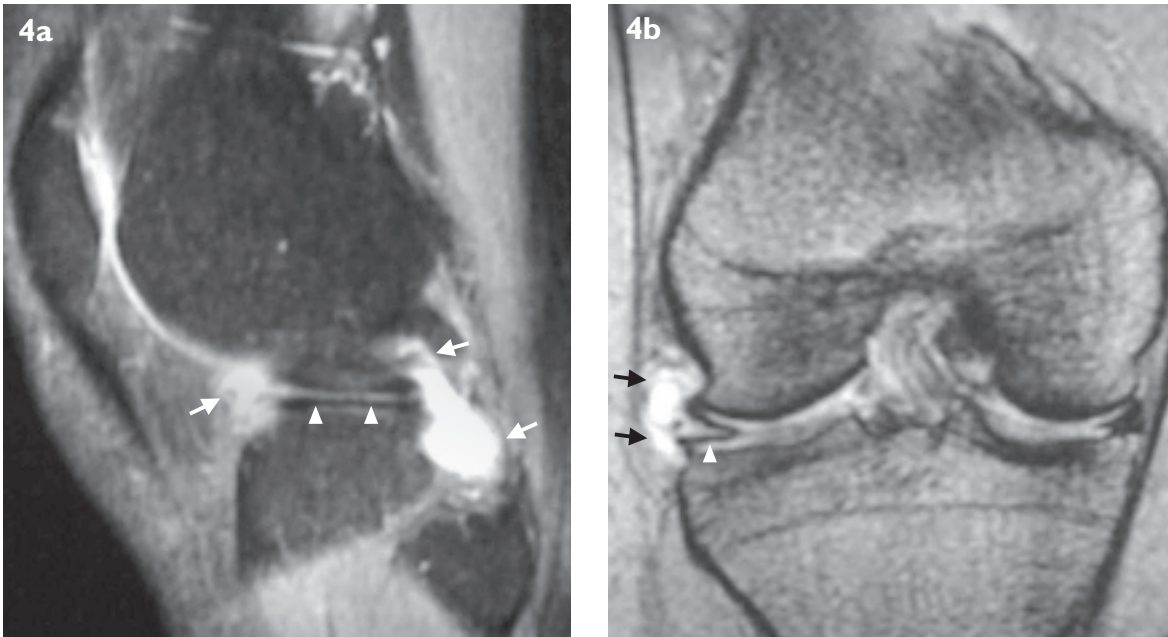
Lateral meniscal cyst. (a) Sagittal T2-weighted MR image shows an extensive horizontal tear of the lateral meniscus (arrowheads), with extension into a cyst (arrows) adjacent to the tear. (b) Coronal T2*-weighted MR image shows the communication between the horizontal tear (arrowhead) and the adjacent meniscal cyst (arrows).
